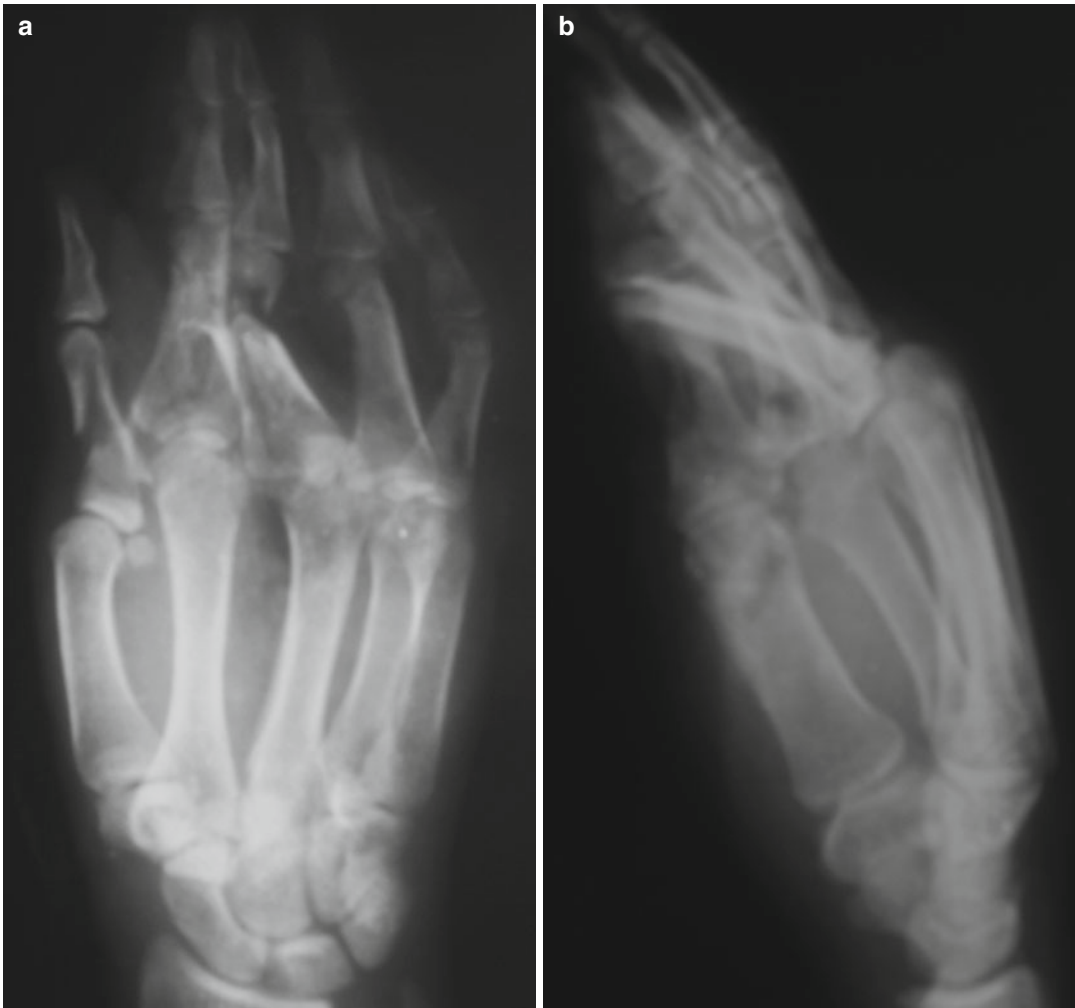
(a, b) X-rays of patient in case
